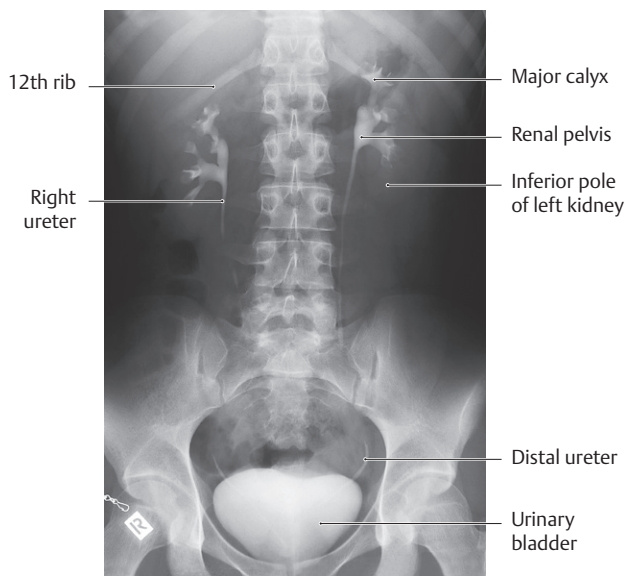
Radiograph of intravenous pyelogram
